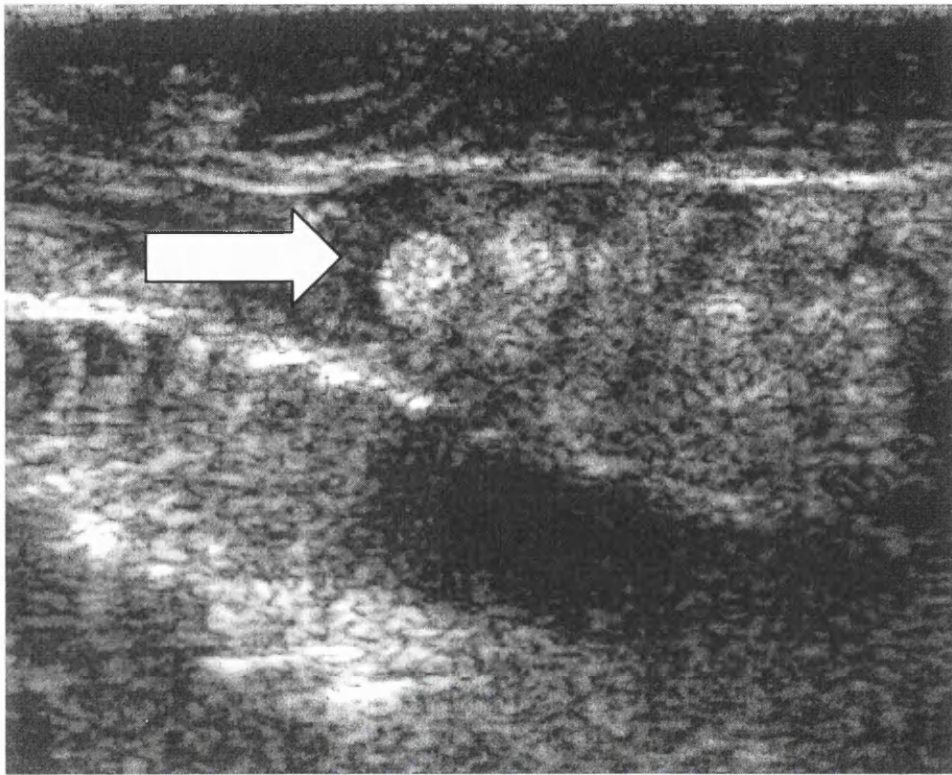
An ultrasound image showing the end of an ovary in a female rainbow trout from the January 2002 sampling.
